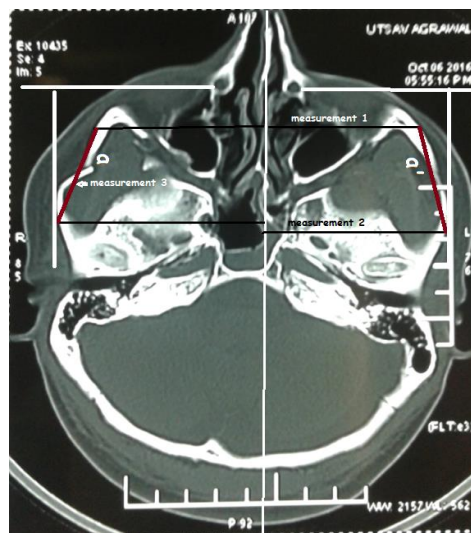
Axial CT image indicating landmarks, reference lines & measurements.⁽¹¹⁾
